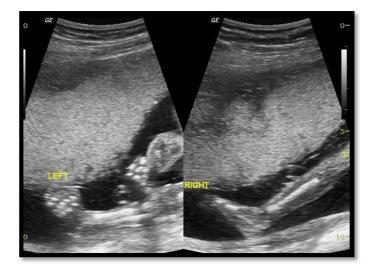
A 2 - D ultrasonography of the fetal lower limb showing clubfoot in the left foot and normal right foot (Patel, 2014)
